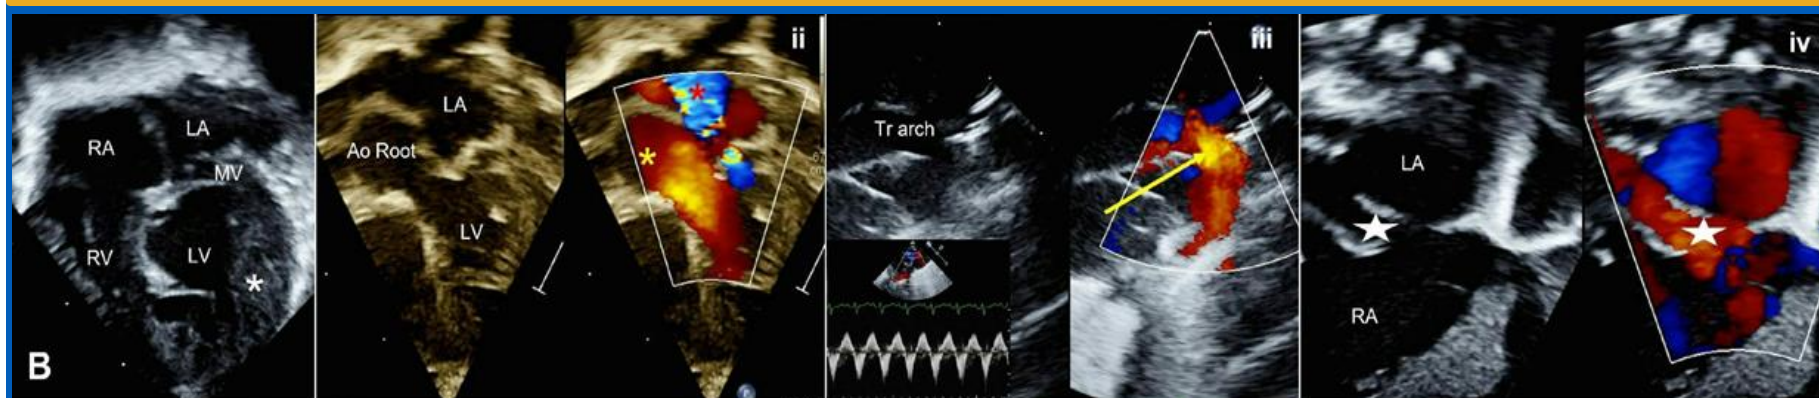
Image B- Postnatal transthoracic echocardiogram: i. Apical 4-chamber view showing dysplasia of MV and LV noncompaction. ii. Apical 5-chamber view showing severe aortic insufficiency with concomitant mitral regurgitation (yellow and red asterisks respectively). iii. Suprasternal view showing flow reversal across the arch and brachiocephalics contributing to the circular shunt (inset shows Doppler pattern across descending aorta with diastolic flow reversal and low-velocity forward flow in systole). iv. Subcostal sagittal view showing borderline restrictive left-to-right flow across foramen ovale (white star).
